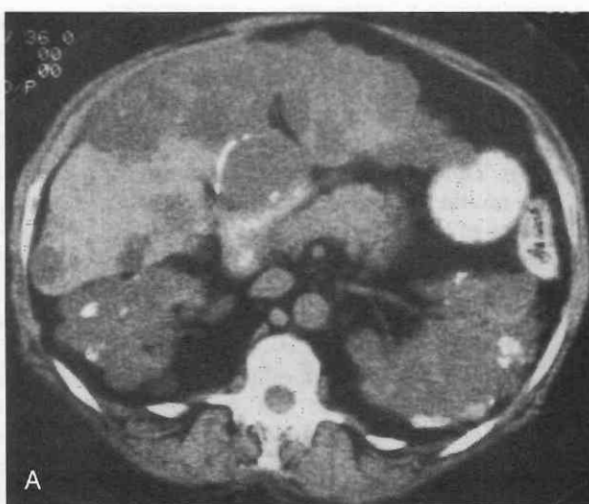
Polycystic kidney and liver disease in a 48-year-old woman. *A*, Noncontrast CT scan shows multiple cysts involving the liver and both kidneys. Several calcifications are demonstrated. *B*, T1-weighted image (TR = 450 msec, TE = 15 msec) shows multiple low-signal-intensity cysts of both the liver and kidneys. Several cysts demonstrate high-signal intensity, which corresponds to hemorrhage (arrows). *C*, T2-weighted image (TR = 2500 msec, TE = 90 msec) shows the cysts with varying degrees of hyperintensity. Areas of signal void that correspond to calcifications are better visualized (arrows).
